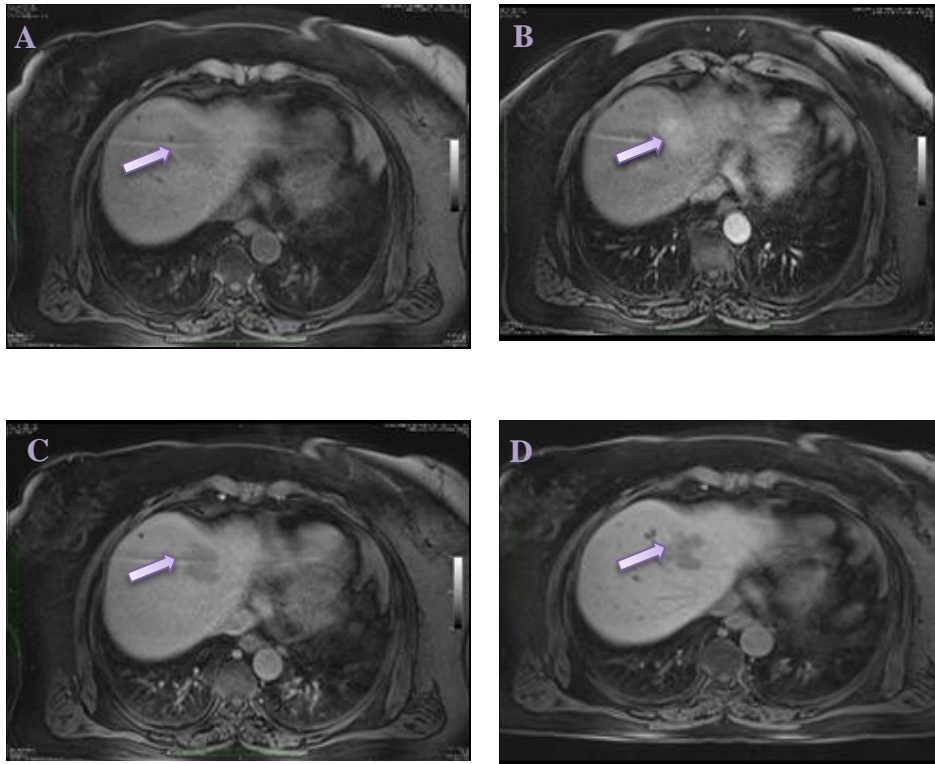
Dynamic MRI study of a Steatotic HCA in pre-IVC (A), arterial (B), delayed (C) and hepatospecific (D) phases. The lesion appears hypointense before contrast injection; the tumor is hypervascular in the arterial phase, and becomes hypointense in the delayed and hepatospecific phases.
